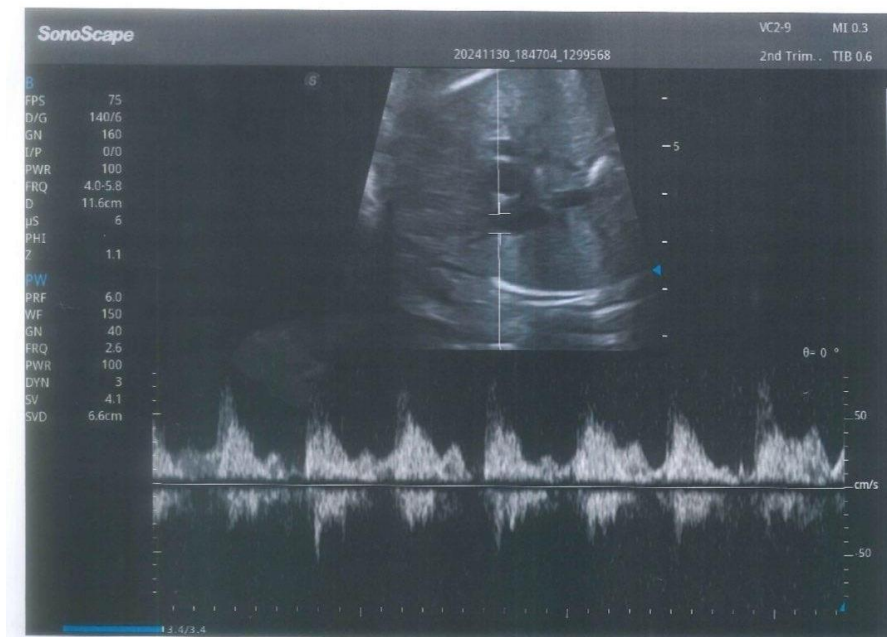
A 22 years old 2ndG, admitted for routine antenatal examination, GA38 weeks + 3days, SLF, HR (125 b/m), good perception of fetal movement, AFI(15), placental grading grade 3, colon grading grade 2, Doppler examination: MPA RI(0.71), PI(1.8), AT(60ms), ET(165ms), AT/ET(0.36), The neonatal outcome delivery 48 hours_ NICU admission for RDS (NO) .
